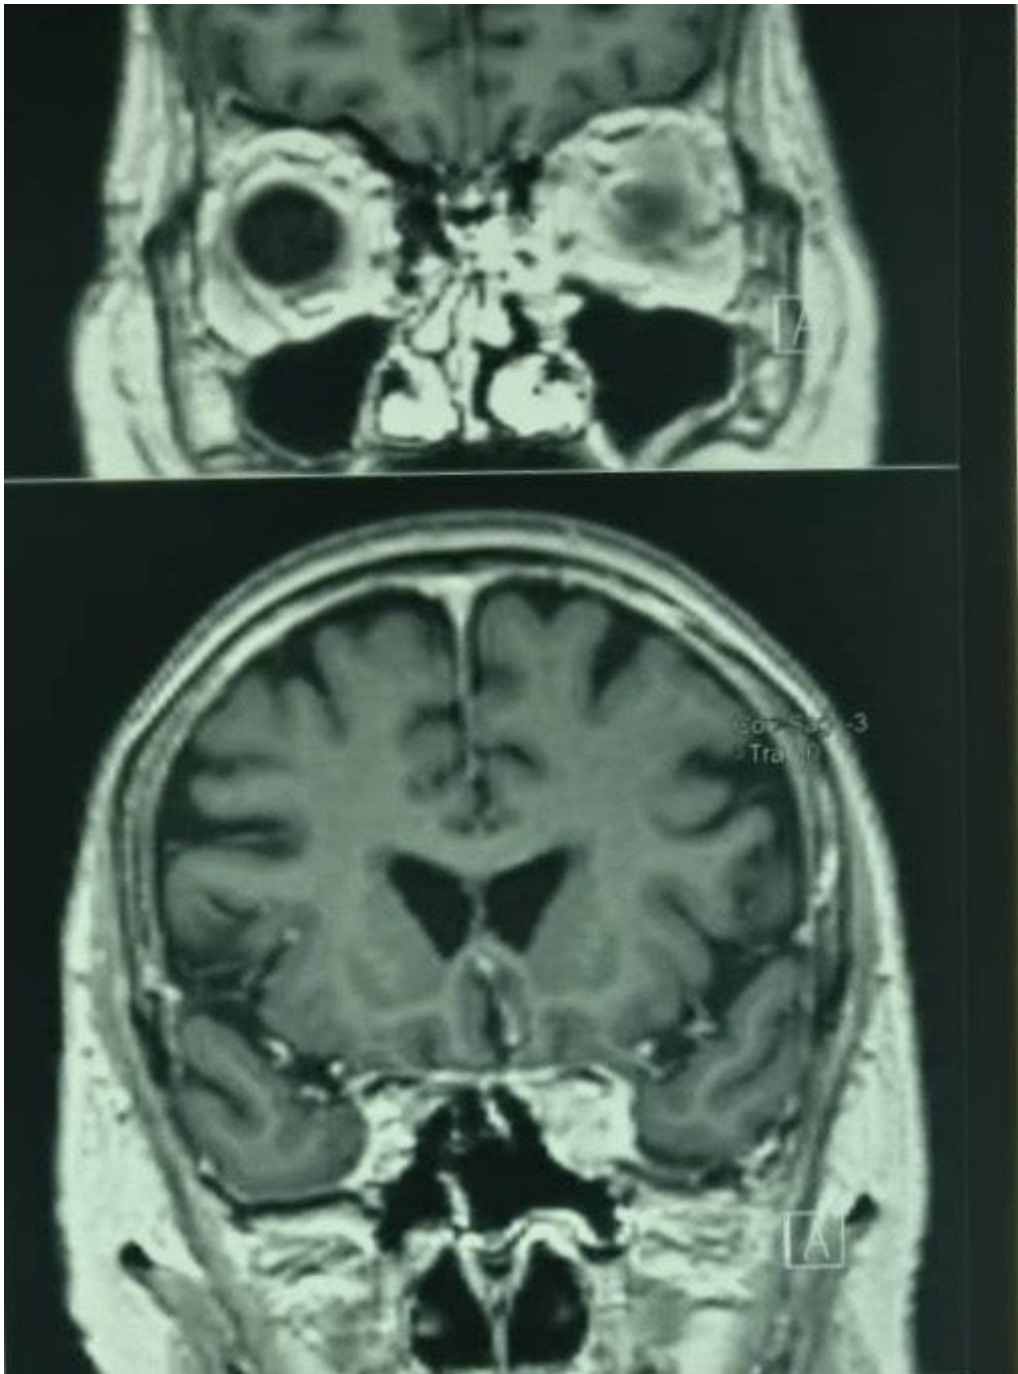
Figure B & C: MRI brain and orbit showed dural based lesion involving left orbital apex with extension into the left cavernous sinus and left temporal fossa with local mass effect and compression onto the left optic nerve.
